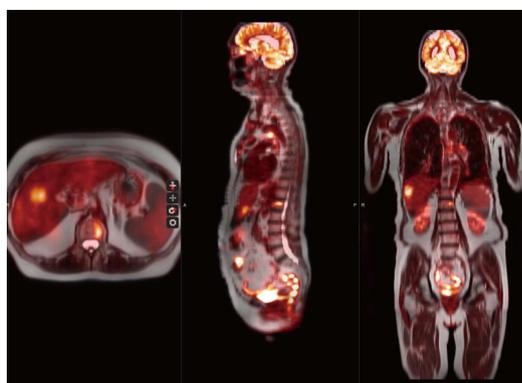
A 66-year-old female with history of breast cancer status post resection and chemoradiation presents with chest pain. Whole-body PET-MRI reveal multiple abnormal nodular soft tissue masses within the lungs, mediastinum, ribs, liver and lumbar spine with increased FDG uptake consistent with metastasis in this patient with breast carcinoma. PET: Positron emission tomography; MRI: Magnetic resonance imaging; FDG: ¹⁸F-fluorodeoxyglucose.
